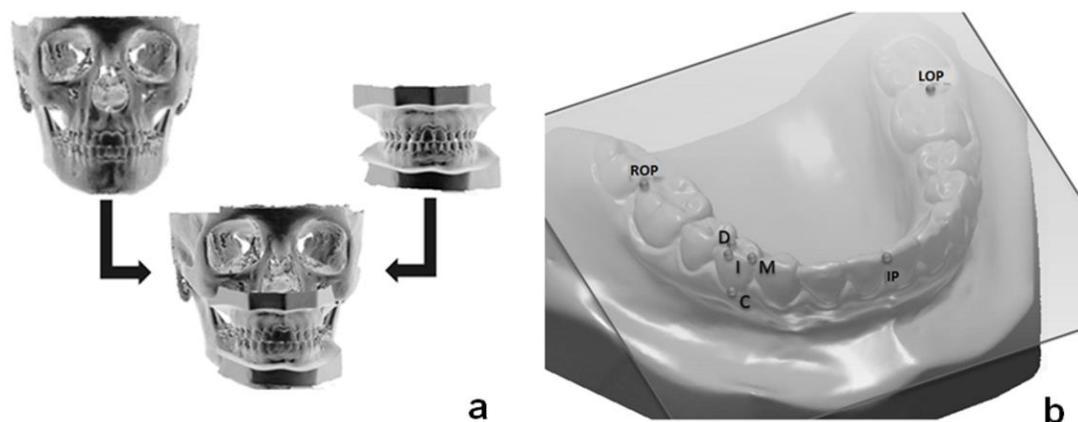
(a) Superimposition of digital models and images acquired using cone beam computed tomography (CBCT). (b) Reference points marked on the surface of digital models. C: cervical point; I: incisal point; D: distal point; M: mesial point; ROP: right occlusal point; LOP: left occlusal point; IP: interincisal point.
